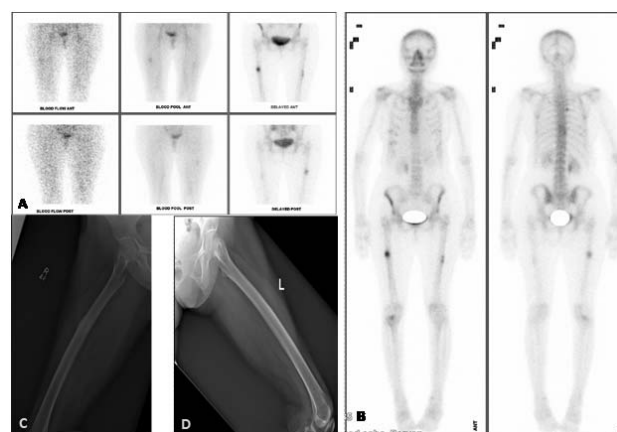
Dynamic ^{99m}Tc MDP bone scintigraphy showing active osteoblastic lesions involving lateral cortices of both femur (advanced lesion on right and early evolving on left) in a patient has been on bisphosphonate treatment for 4 years presented with right thigh pain. (C) Right femur plain X-ray in same patient showing incomplete atypical proximal fracture concomitant with osteoblastic lesion visible on bone scintigraphy. (D) Left femur plain X-ray in same patient showing no concomitant radiological abnormality in middle 1/3rd of lateral cortex.
